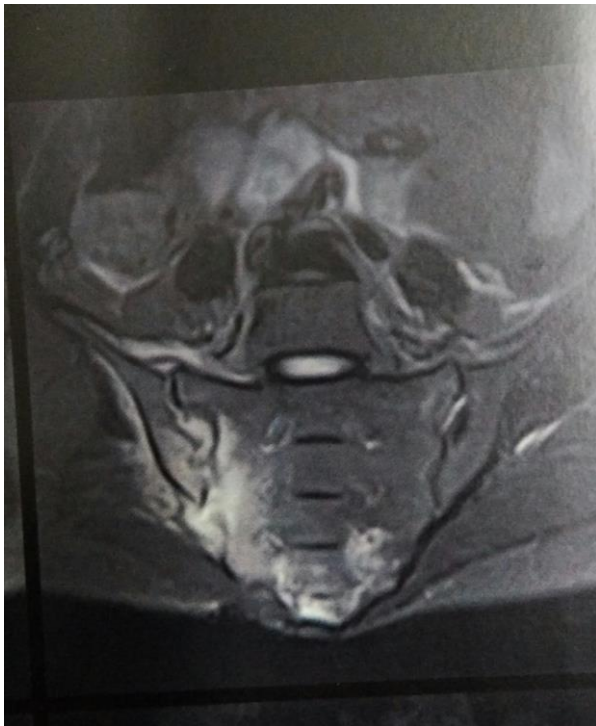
MRI picture of sacroiliitis
